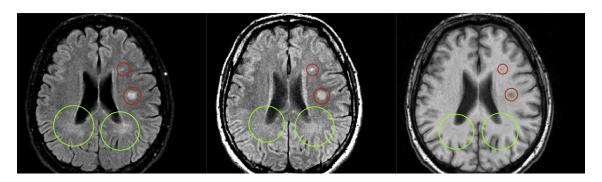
Difference between focal lesions (red) and diffuse regions of visible-abnormal WM (green). From left to right: FLAIR, PD and T1. [7].
